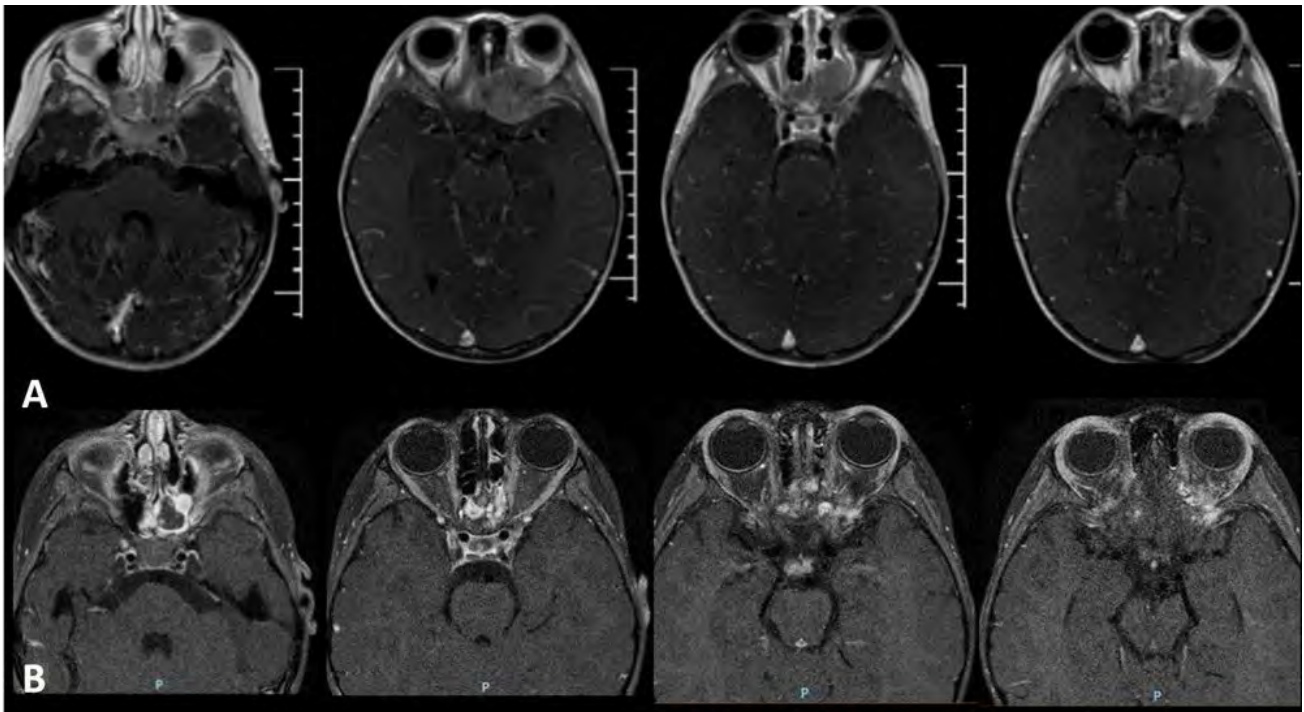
Comparative T1WI post gadolinium MRI (A. pre adjuvant chemotherapy; B. post adjuvant chemotherapy after 8 weeks of adjuvant chemotherapy) demonstrating a significant reduction in the tumor mass, absence of periorbit involvement and resolution of the proptosis in the left eye.
